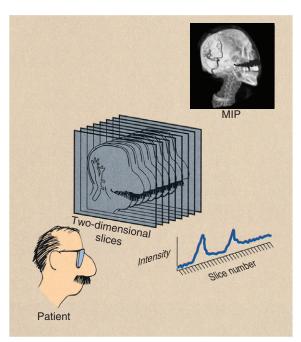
A maximum intensity projection reconstruction creates a three-dimensional image from multislice two-dimensional data sets. The result is a computed tomographic angiogram.
